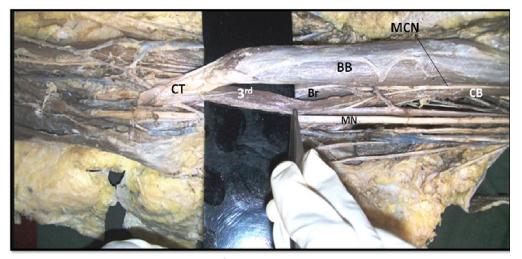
Showing third head (3rd) of biceps brachii originating in common with brachialis (Br). BB: Biceps brachii, CB- coracobrachialis, CT: Common tendon of biceps, MN: Median nerve, MCN: Musculocutaneous nerve
